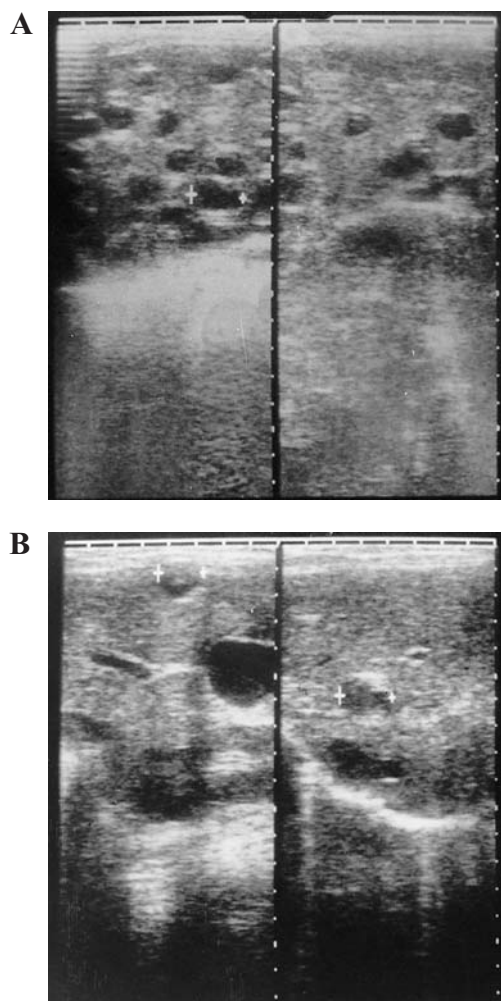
Abdominal ultrasonography. Multiple liver cysts before (A) and 20 months after (B) mebendazole treatment. (Note that some of the smaller cysts disappeared or shrank with treatment whereas two cysts became larger).
